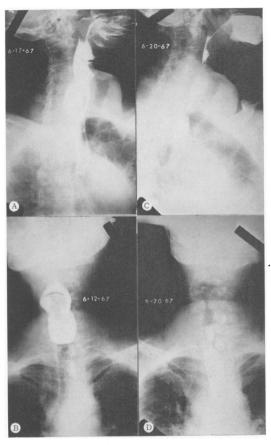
Esophageal roentgenograms in patient with a moderate-sized pharyngo-esophageal diverticulum. A and B, Before operation. C and D, Five days after myotomy and suture suspension of the diverticulum.
